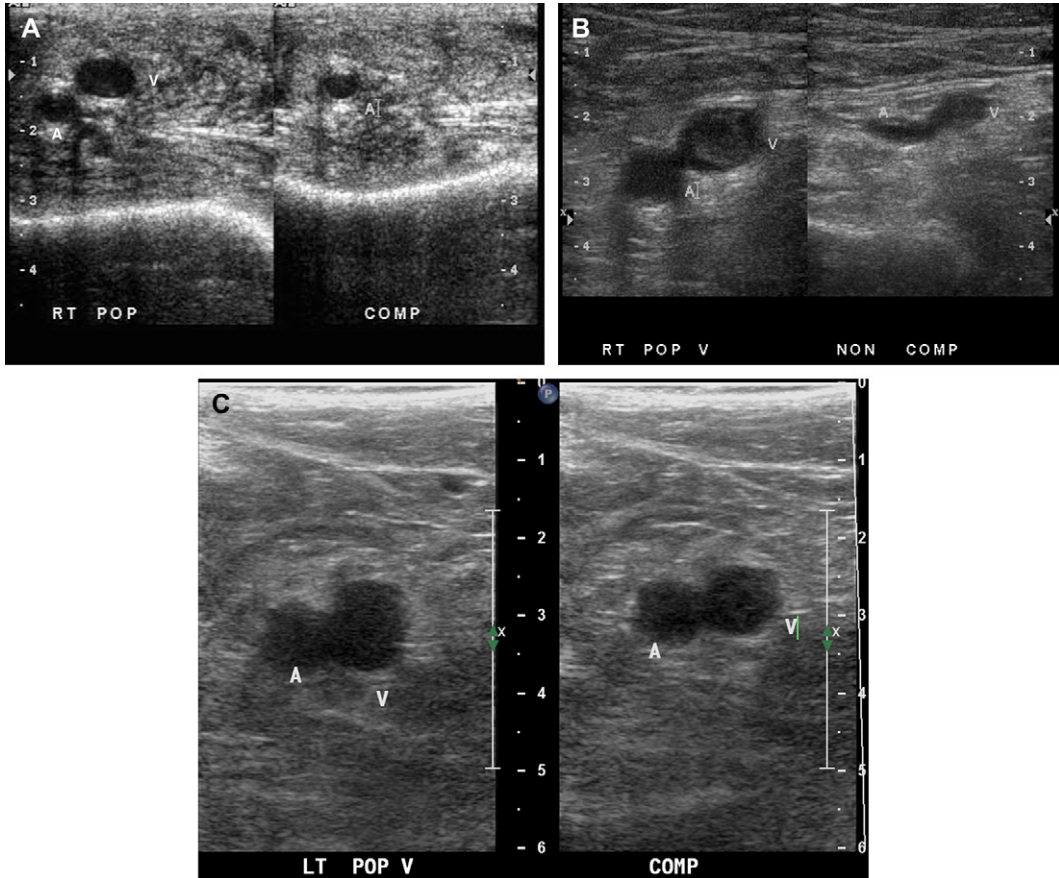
Transverse sonograms demonstrating compression response of normal and thrombosed veins. (A) Compression of a normal popliteal vein completely collapses the venous lumen. Only the popliteal artery (A) remains on compression view. (B) Compression of a nonocclusive thrombosed popliteal vein partially collapses the venous lumen (V). (C) Compression of a completely thrombosed popliteal vein prevents venous coaptation.
